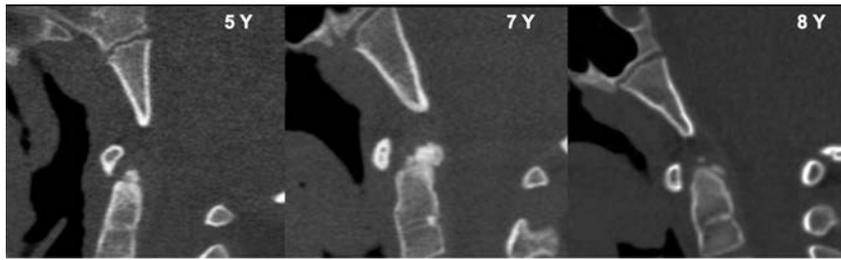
Sagittal CT cervical spine images in 3 children of different ages show the variable appearance of the os terminale.
